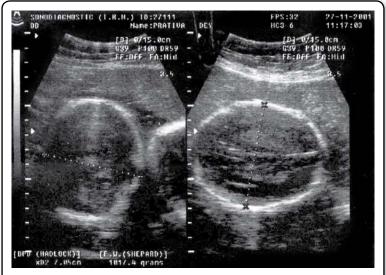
Ultrasonography of a twin pregnancy showing two fetal heads [By courtesy—Dr. (Mrs) S Ghosh and Prof BN Chakravorty, Director, IRM. Kolkatal
